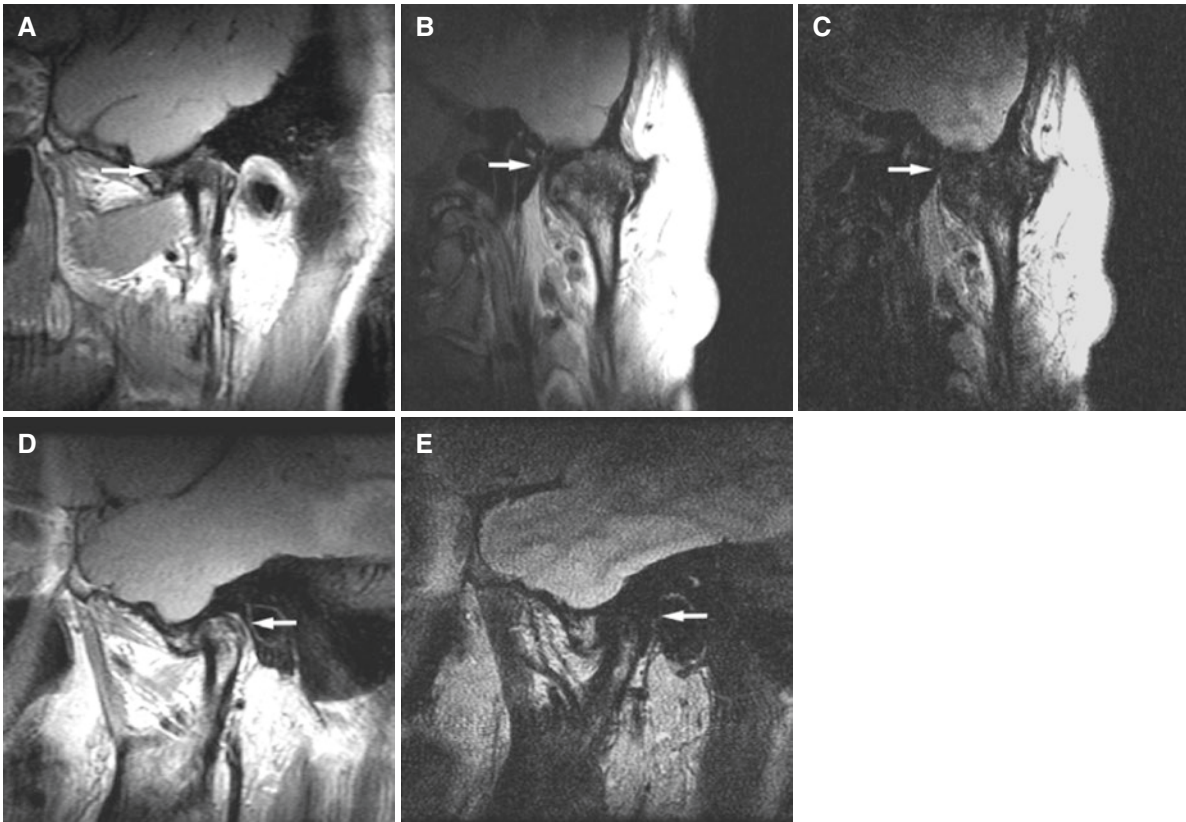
Ankylosis of the right (A, B, C) and left (D, E) joints. (A) Oblique sagittal T1-weighted MRI shows no delineation of the disc, fossa, or condyle (*arrow*). (B) Oblique coronal T1-weighted MRI confirms loss of structures (*arrow*). (C) Oblique coronal T2-weighted MRI shows no structures or effusion (*arrow*). (D) Oblique sagittal
